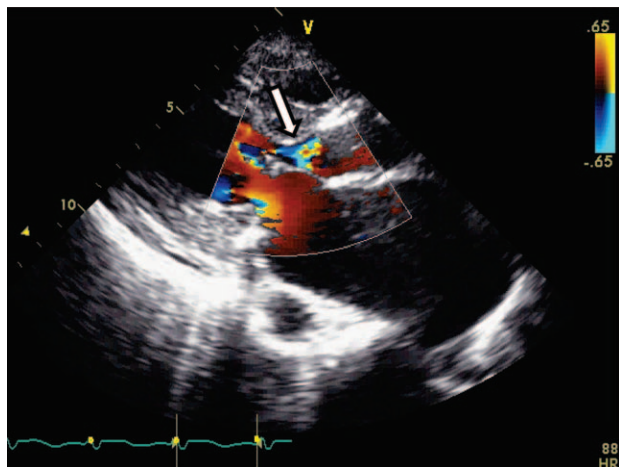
Parasternal longitudinal axis transthoracic echocardiography view showing mild paravalvular leak post-transcatheter heart valve deployment. Arrow indicates the site of paravalvular leak.
